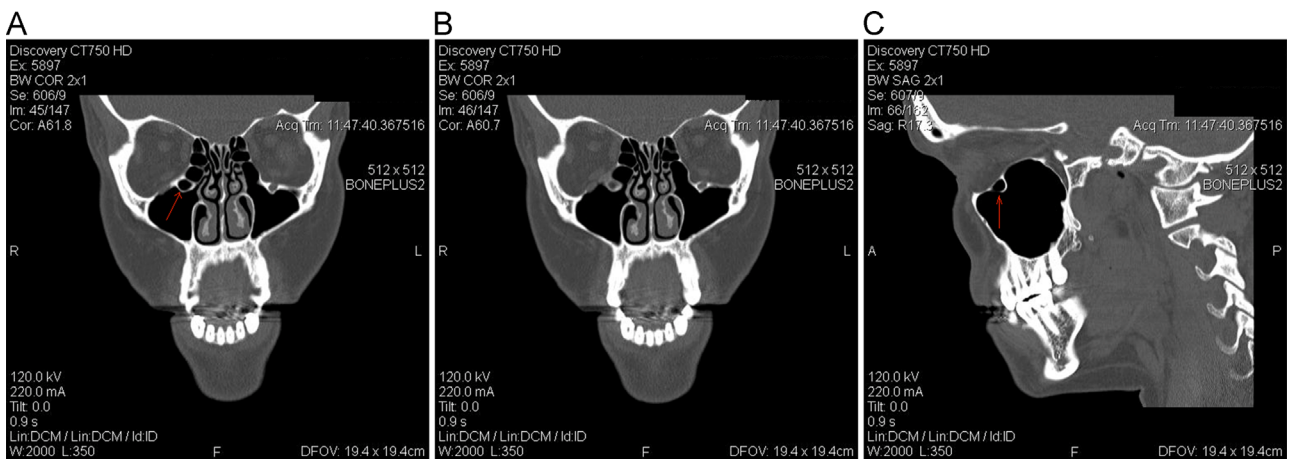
(A–C) Computed tomography coronal and sagittal views of orbits demonstrating contralateral capsule of ethmoid cells with anterior air cell (Haller cell) at medial orbital floor (arrow). Sagittal view demonstrates presence of Haller cell at right orbital floor (arrow).
